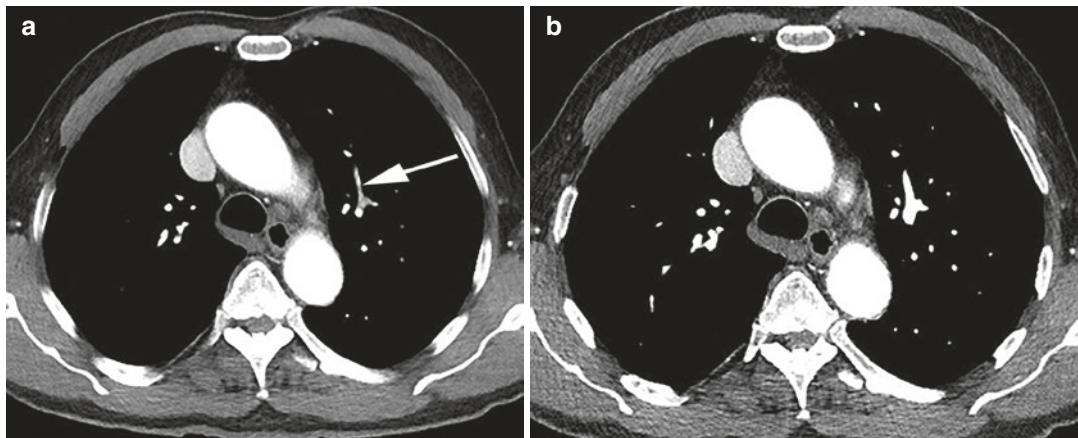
Volume averaging artifact in an 83-year-old man. Axial contrast-enhanced CT (a) with 5 mm collimation appears to show low attenuation in a central artery within the left upper lobe (arrow). (b) The source images
